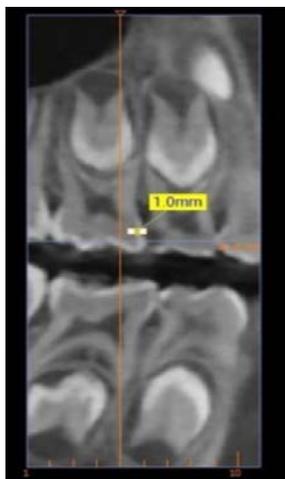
Measuring CBCT radiographic lesion depth (Author's)
